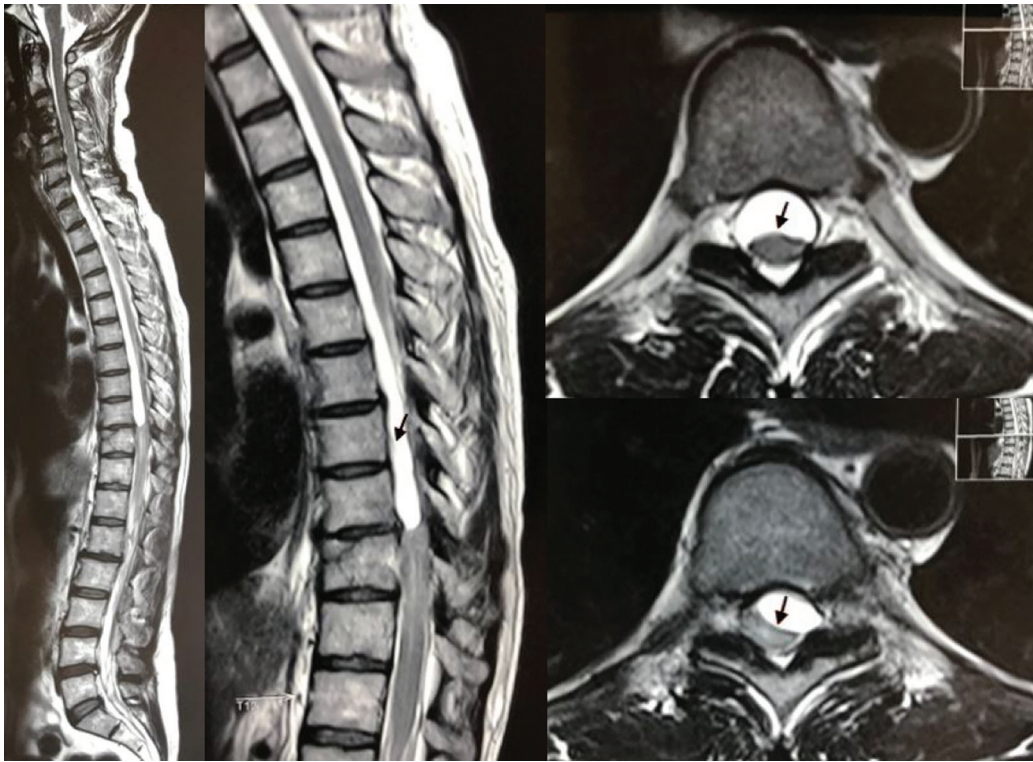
Sagittal T2-weighted magnetic resonance imaging showing an old fracture at the T10 vertebral body; space widening between the T9-T10 spinous processes, suggesting chronic ligament rupture; alteration of the spinal-cord signal at the T9, T10 and T11 levels, consistent with myelomalacia; posterior adhesion of the spinal cord at the T7-T9 level, and anterior adhesion at the T9-T12 level, associated with adhesive arachnoiditis and an arachnoid cyst at these levels. The white arrows show the boundaries of the cyst and posterior spinal adherence.
